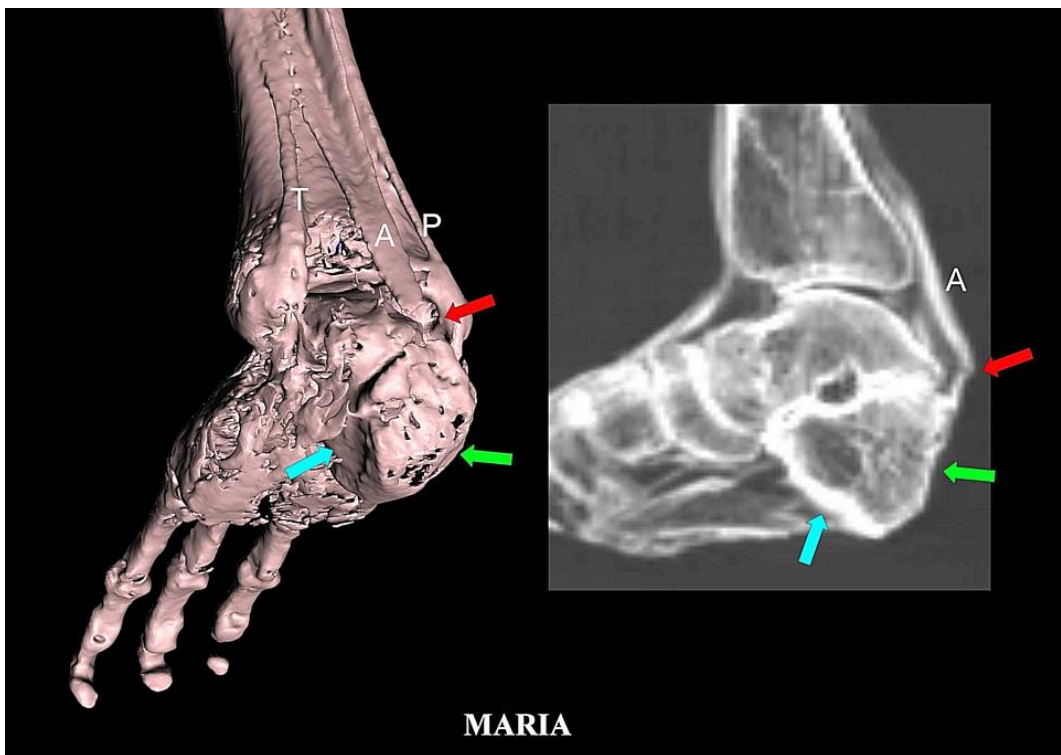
3D CT (*left*) and 2D sagittal CT scan (*right*) of right heel showing truncated posterior part of the calcaneum (*green arrows*) including the attachment part of Achilles tendon (*red arrows*). Note bony regrowth at the cut end of calcaneum with thin cortex (*green arrows*) as compared with the normal thick cortex (*blue arrow*).
